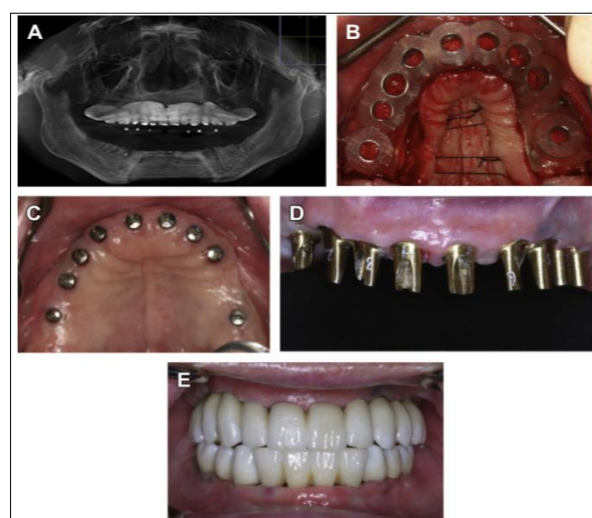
(A) CBCT scan produced using a radiopaque resin - a duplicate. (B) Stereolithographic surgical
